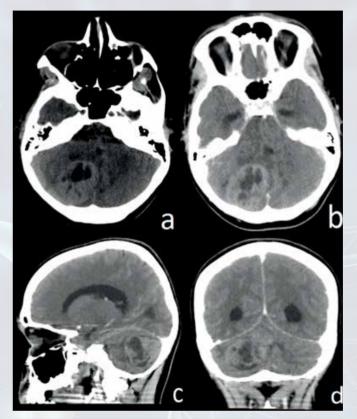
Axial brain CT without crontrast (a) and with contrast (b), sagittal (c) and coronal (d) with contrast. Intra-axial tumor in the right cerebellum hemisphere, with well-defined borders, heterogeneous appearance, with central cystic area (necrotic) and contrast capture.
